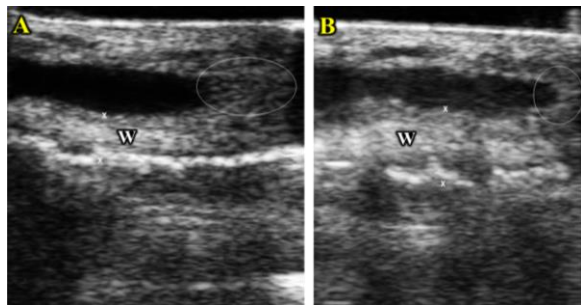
Ultrasonographic examination of buffalo teat; in normal (A) and in subclinical mastitis (B). Showing the teat wall (W) and rosette of Furstenberg (circle).
